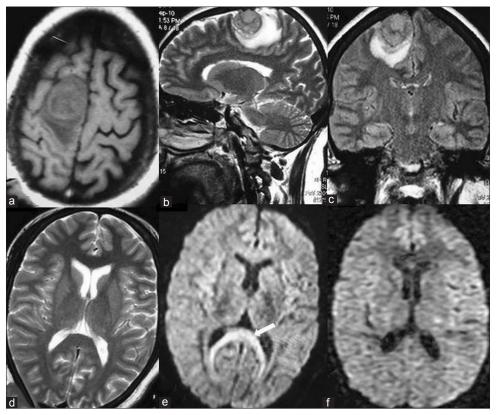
Magnetic resonance imaging (Brain) of case 2, with localization related epilepsy, showing a right-sided well defined parafalcine extra-axial space occupying lesion, with perilesional edema, in T1-weighted axial (a), T2-weighted sagittal (b) and coronal (c) images. T2-weighted image (d), axial section, focussing on the corpus callosum appears normal while a uniform hyperintensity of the splenium of corpus callosum ("Boomerang sign") on diffusion-weighted image (e) is evident. Follow up diffusion-weighted image (f), done at 1 week, depicts complete disappearance of altered signals in the splenium
